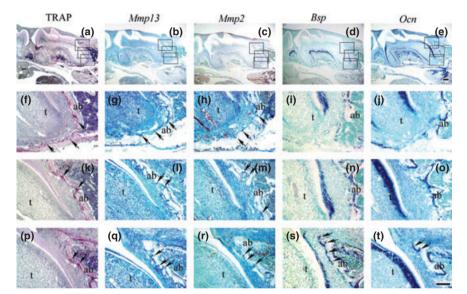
Changes of TRAP activity and gene expression at PN 15. At PN 15, occlusal alveolar bone was disappeared. TRAP positive cells could be identified in apical two-third of the alveolar bone around the tooth (a, f, k, p, indicated by arrows), however, absent on the inner surface of occlusal one-third site (p). Mmp2 and 13 were also detected in apical two-third of the alveolar bone (g, h, l, m, q, r, indicated by arrows), but not on the inner surface of occlusal one-third part (q, r). The expression of Bsp and Ocn was detectable on the inner surface of one-third occlusal alveolar bone (s, t), however, absent in the other surface of alveolar bone around tooth (i, j, n, o, indicated by arrows). ab, alveolar bone; e, enamel; am, ameloblast. Scale bars =  $100\mu m$
